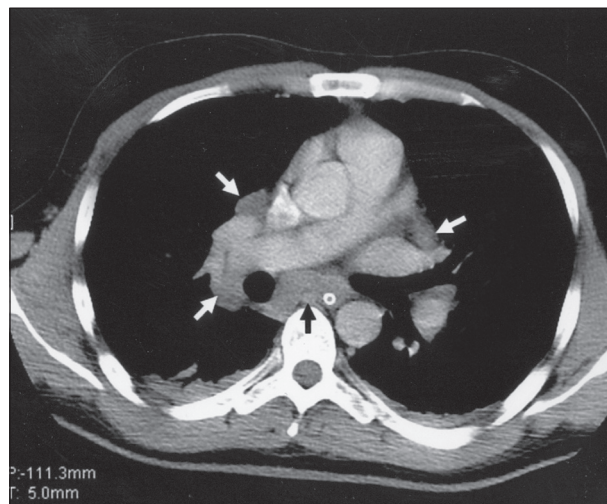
CT chest, post contrast axial mediastinal cut revealing multiple bilateral hilar and sub-carinal lymphadenopathy
